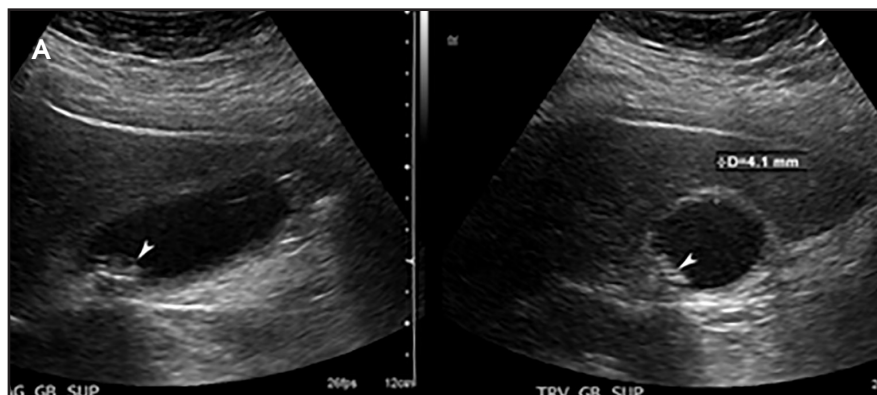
A 25-year-old woman presented with a 2-day history of epigastric pain and abnormal liver function tests. The patient received 4 mg IV morphine approximately 12 hrs prior to HBS. Sagittal and transverse static images from a limited right upper quadrant ultrasound demonstrate a nondistended GB with mild wall thickening (4.1 mm) and intraluminal gallstones (arrowheads). Sonographic Murphy sign was negative, but its interpretation was hampered by analgesic use. The study was interpreted as equivocal and HBS was recommended.
